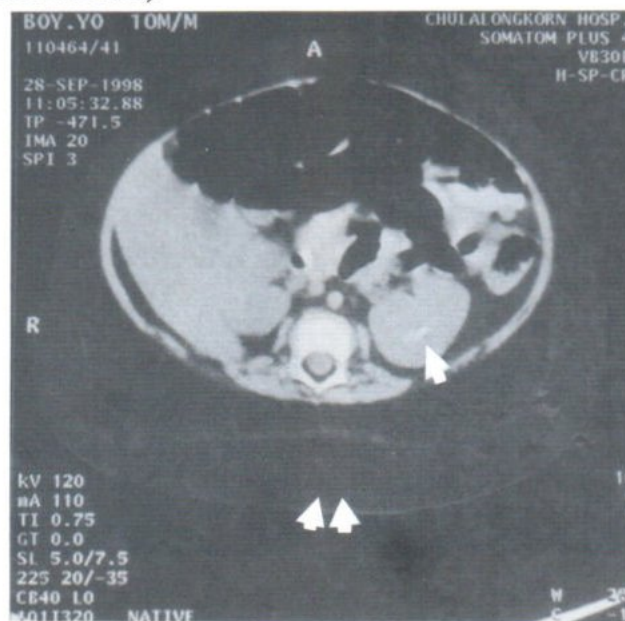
Unenhanced CT scan shows a well-defined rounded left adrenal soft tissue density mass (arrowhead).
